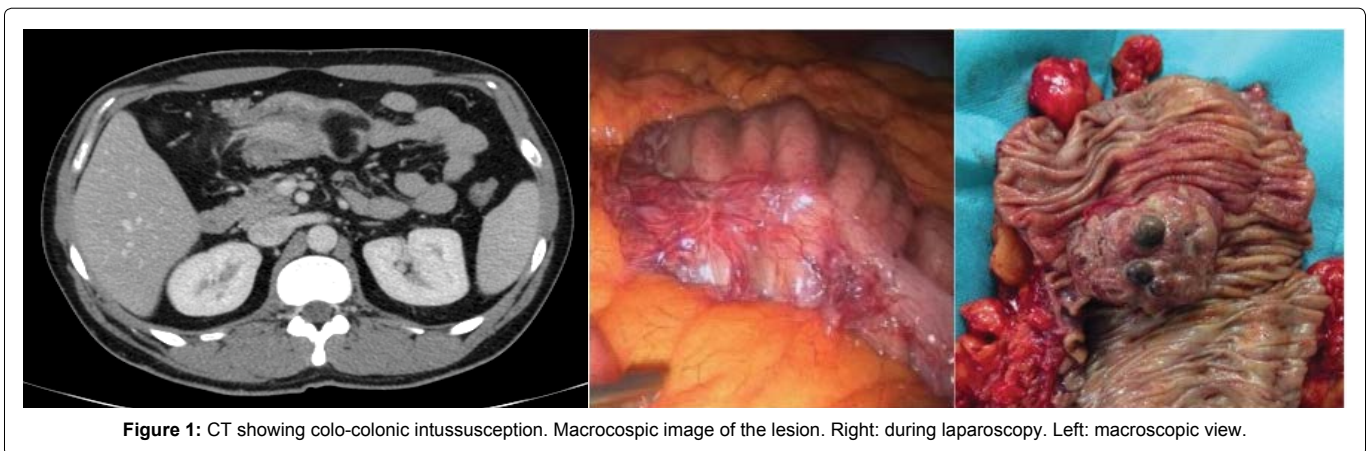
CT showing colo-colonic intussusception. Macroscopic image of the lesion. Right: during laparoscopy. Left: macroscopic view.
